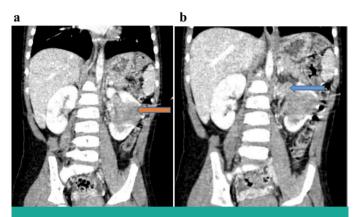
Coronal section CT image of the patient; a) CT image of a coronal section demonstrating a mass originating from the mid-pole of the left kidney (orange arrow), b) Left renal vein invasion (blue arrow)
